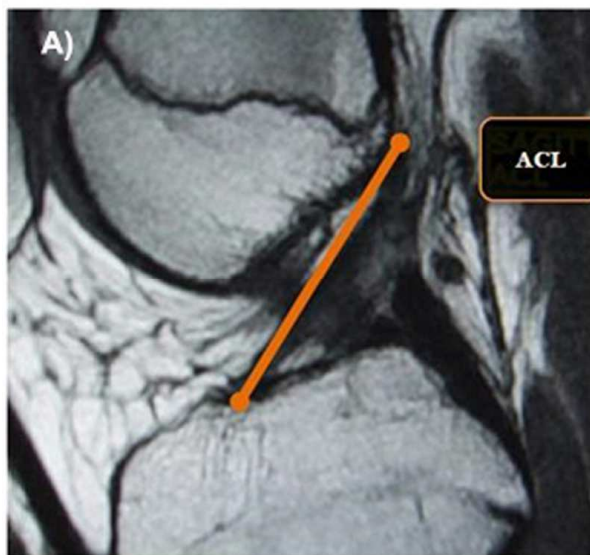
(A) ACL vector in sagittal MRI view. (B) PCL vector in sagittal MRI view.
